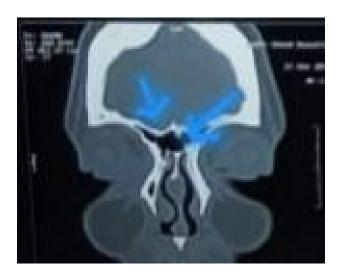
CT scan PNS coronal showing both frontal sinuses connected in the mid line with no bony boundaries.
